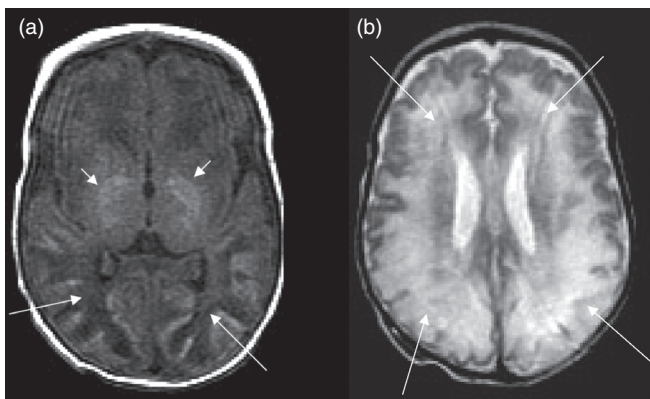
Sulfite oxidase deficiency with thalamic (short arrows) and diffuse white-matter involvement (long arrows) on (a) axial T1 and (b) T2 MRI.
